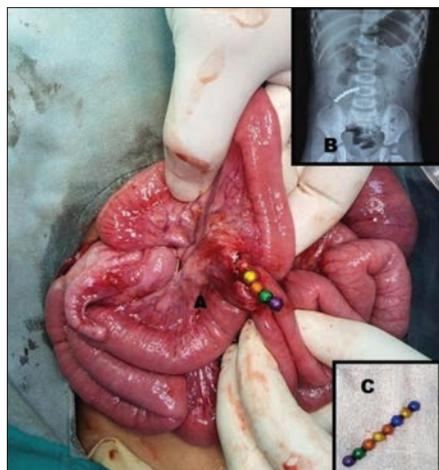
Magnets are being removed from adhered and perforated ileum (A), X-ray showing beaded foreign body (B) and magnet after removal (C)
